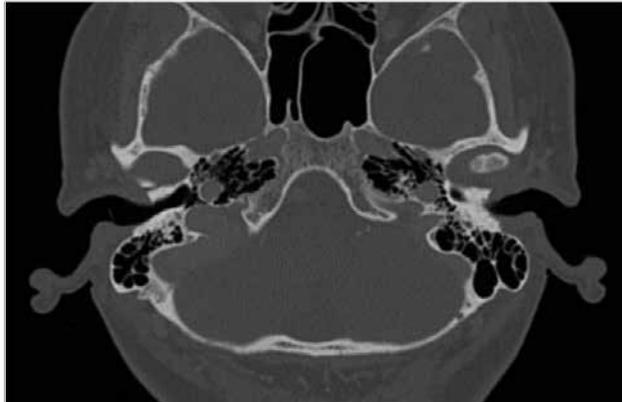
Axial high-resolution temporal bone computed tomography shows bilateral symmetry and almost equal diffuse pneumatization of the petrous apex
